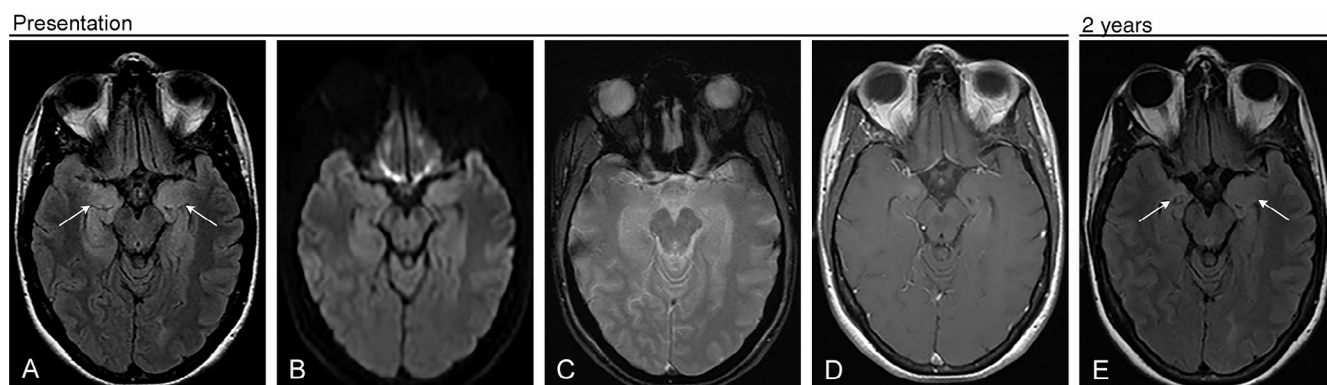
Limbic encephalitis. A 29-year-old female presented with several months of hallucinations, seizures, hypersomnolence, and amnesia. (A) FLAIR sequence shows increased signal in both mesial temporal lobes. DWI (B), gradient echo (C), and postcontrast T1-weighted images (D) show no restricted diffusion, hemorrhage, or enhancement. CSF was positive for voltage-gated potassium channel antibodies, and a diagnosis of voltage-gated potassium channel antibody-induced limbic encephalitis was made. Follow-up FLAIR sequence performed 2 years later (E) shows minimal residual FLAIR hyperintensity in the mesial temporal lobes without associated volume loss.
